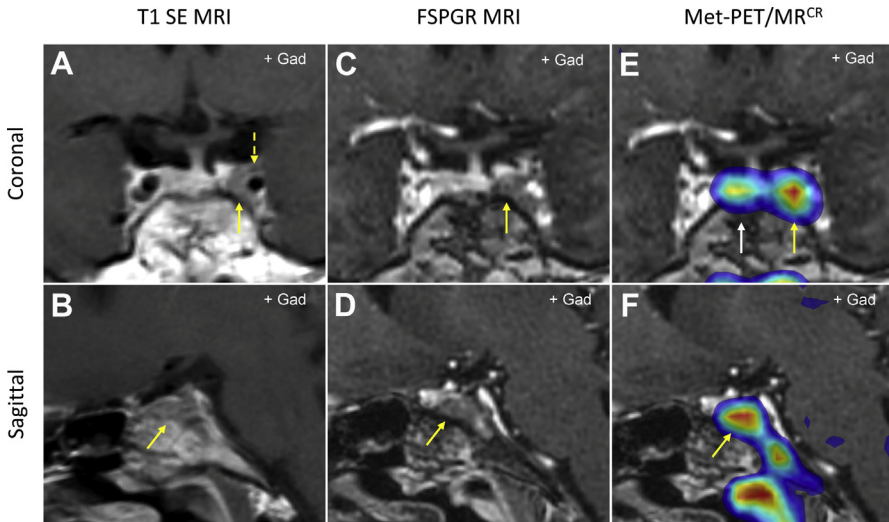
Localization of the site of late recurrence (at 48 months) following primary surgery in a patient with Cushing disease. (A, B) T1 SE MRI demonstrates an area of hypointensity adjacent to (yellow arrow), and possibly invading (yellow dashed arrow), the left cavernous sinus. (C, D) Volumetric (FSPGR) MRI suggests the area of abnormal signal lies medial to the cavernous sinus. (E, F) Met-PET/MR^{CR} shows focal high tracer uptake that corresponds with the findings of FSPGR MRI (confirmed at repeat TSS with complete postoperative biochemical remission); normal physiologic tracer uptake is seen in the right side of the gland (white arrow).
